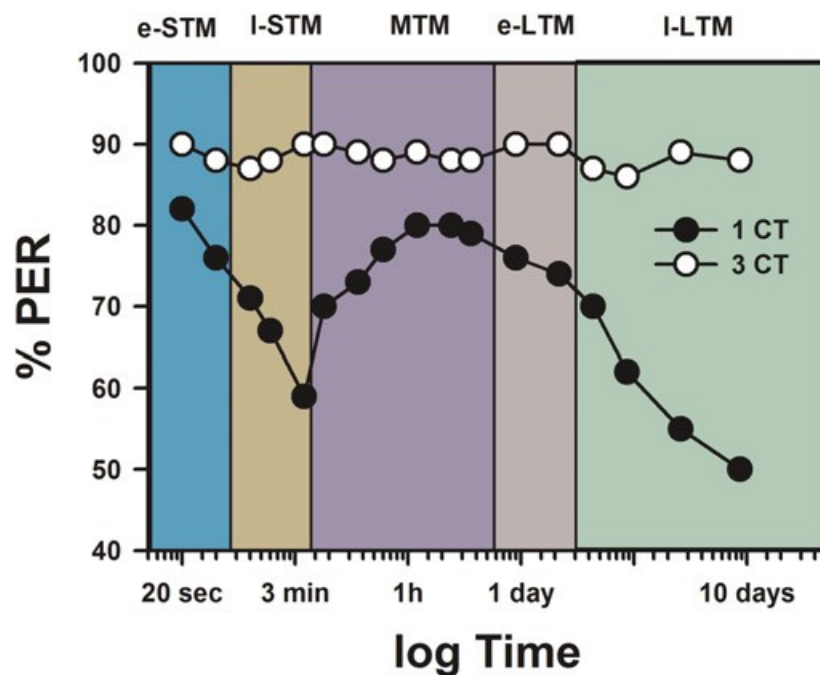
Olfactory memory phases in honeybees. Retention performance (measured as PER percentage: % PER) depending on trial number and the respective underlying memory phases (after Menzel 2001). The memory retention of a single CS-US association (1 CT; black dots) is compared with three (or more) conditioning trials (3 CT; white dots) with 10-min inter-trial intervals. 1 CT allows good retention performance for up until 1 d. 3 CT induce high performance for several days with two forms of long-term memory, one that depends on translation of already-present mRNA (early-LTM: e-LTM), the other critically depending on de novo gene transcription (late-LTM: l-LTM, starting at 3 d); adapted from Giurfa & Sandoz 2012.
